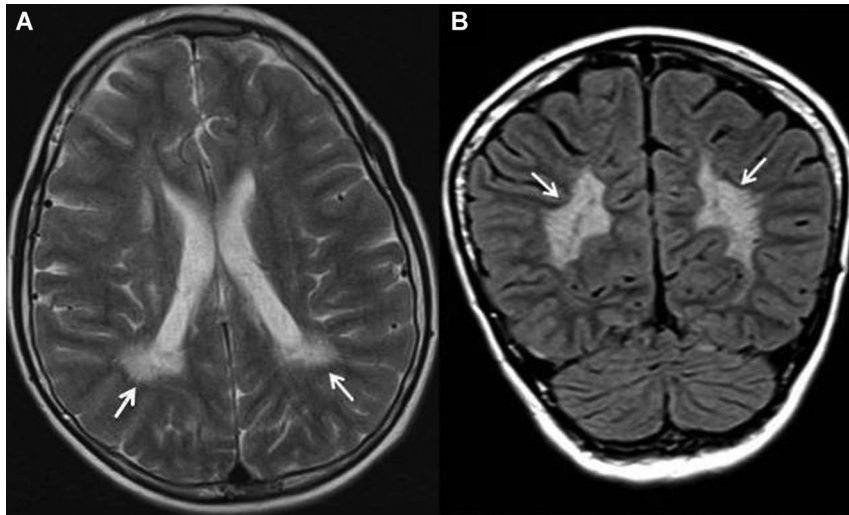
T2 W (A) axial and FLAIR (B) coronal images show symmetric hyperintense changes in supratentorial periventricular and deep white matter.
